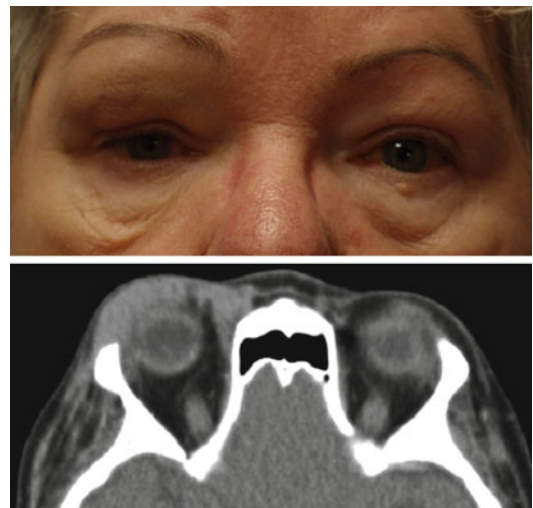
(a) A 69-year-old female presented with swelling of the right brow. (b) Axial CT imaging confirmed lesions of the right and left lids with extension into the right orbit, and biopsy confirmed a diagnosis of MALT lymphoma
